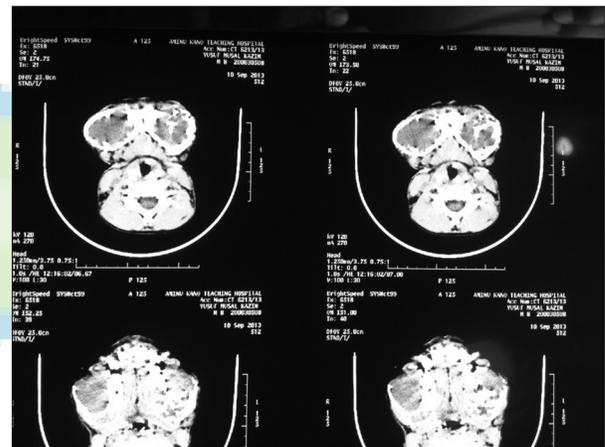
A CT scanogram showed extensive expansile lytic lesion involving the mandible and maxilla with internal septae
